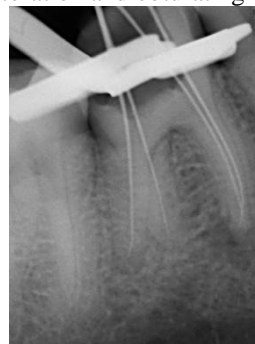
Working length determination with the radiographic method
